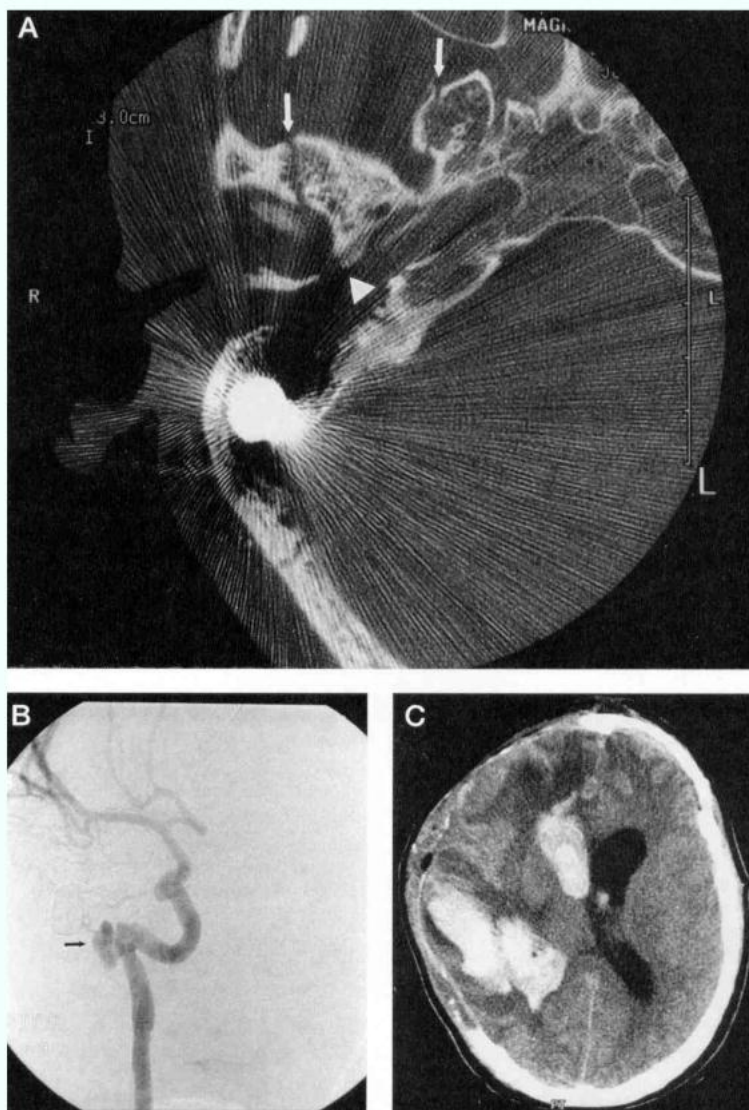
Case 4: (A) Fine-cut temporal bone CT scan showing a bullet fragment lodged in the mastoid bone and fractures (arrows) adjacent to the carotid canal (arrowhead). (B) Oblique right ICA angiogram 4 weeks after admission showing pseudoaneurysm (arrow) that had enlarged compared with study at the time of injury. (C) CT scan showing massive intracerebral hemorrhage from ruptured pseudoaneurysm.
